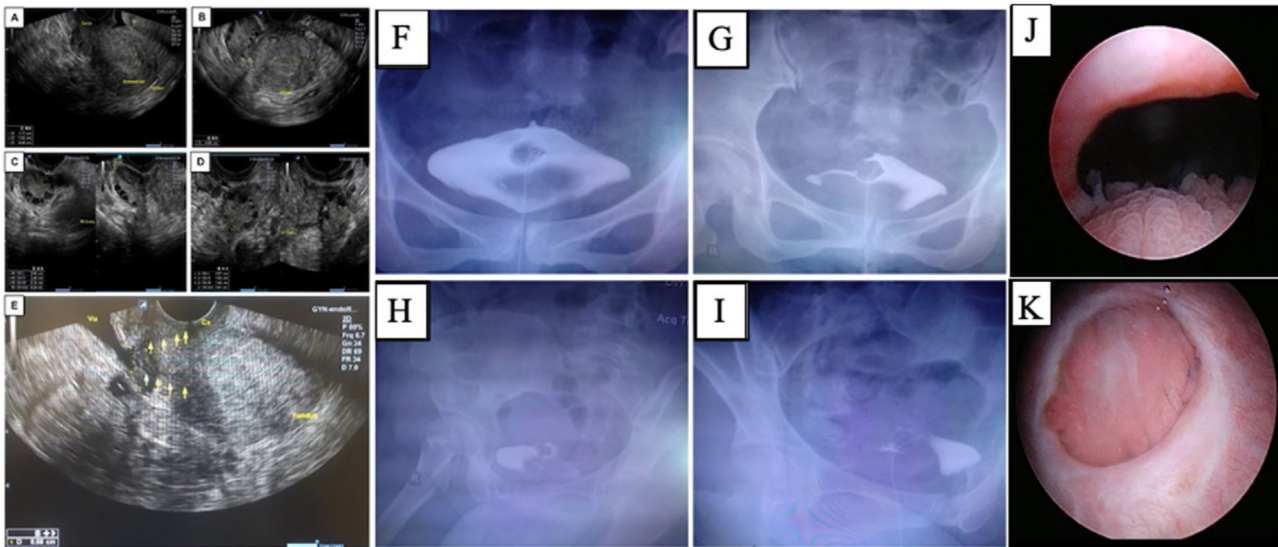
A-E (Ultrasonography examination of the uterus and vesicouterine fistula). Transvaginal ultrasonography demonstrates (A) normal-sized retroflexed uterus with homogenous myometrium. (B) The endometrium thickness is 11 mm. There is no sign of fluid in the uterine cavity. Both right (C) and left (D) ovaries are normal, sized $26 \times 24 \times 27$ mm and $20 \times 16 \times 14$ mm respectively. (E) The appearance of an interconnecting tract between the posterior bladder wall and the lower uterine segment measuring 8 mm in diameter indicating vesicocervical fistula. Fig. 1F-I (HSG result displays a vesicouterine fistula). (F) An anteroposterior view of the pelvis depicting contrast media in the bladder. (G-I) The figures showing the contrast is slowly diminished in the bladder when the balloon insufflation was off and is no longer observed in the bladder after the patient urinated. Fig. 1J-K (Hysteroscopy and cystoscopy results). (J) The hysteroscopic view reveals that there is no access to the uterine cavity from the cervical canal as the orifice merged with the bladder, indicating vesicocervical fistula (K). Cystoscopy examination shows a fistula with endocervical tissue on the posterior part of the bladder measuring.
